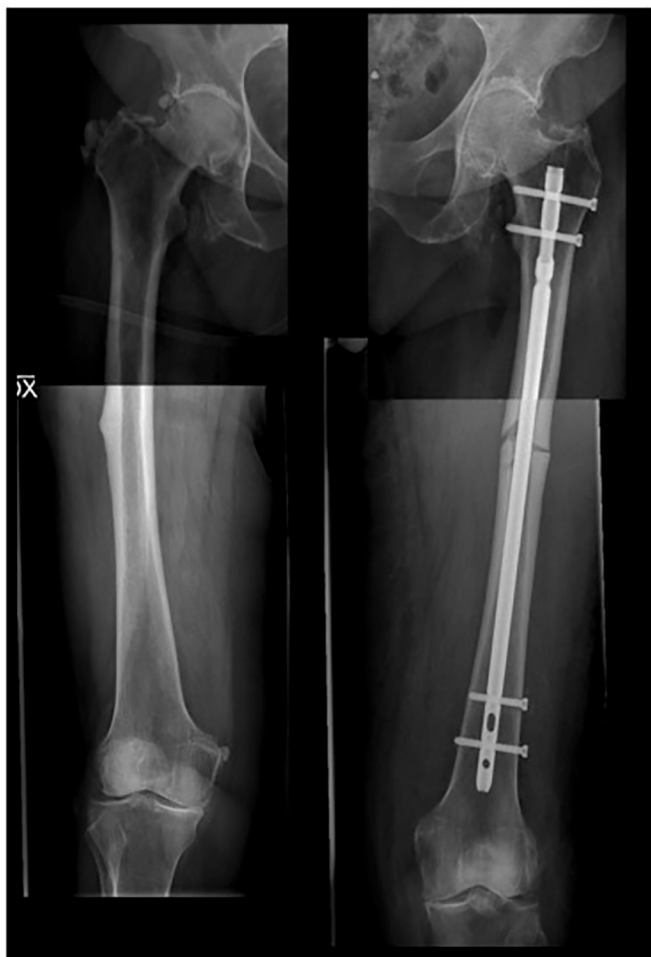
Post-operative radiographs after left femur intramedullary nailing pointing-out atypical pattern features on right femoral shaft. Right: right femur antero-posterior x-rays. Left: left femur antero-posterior x-rays.
